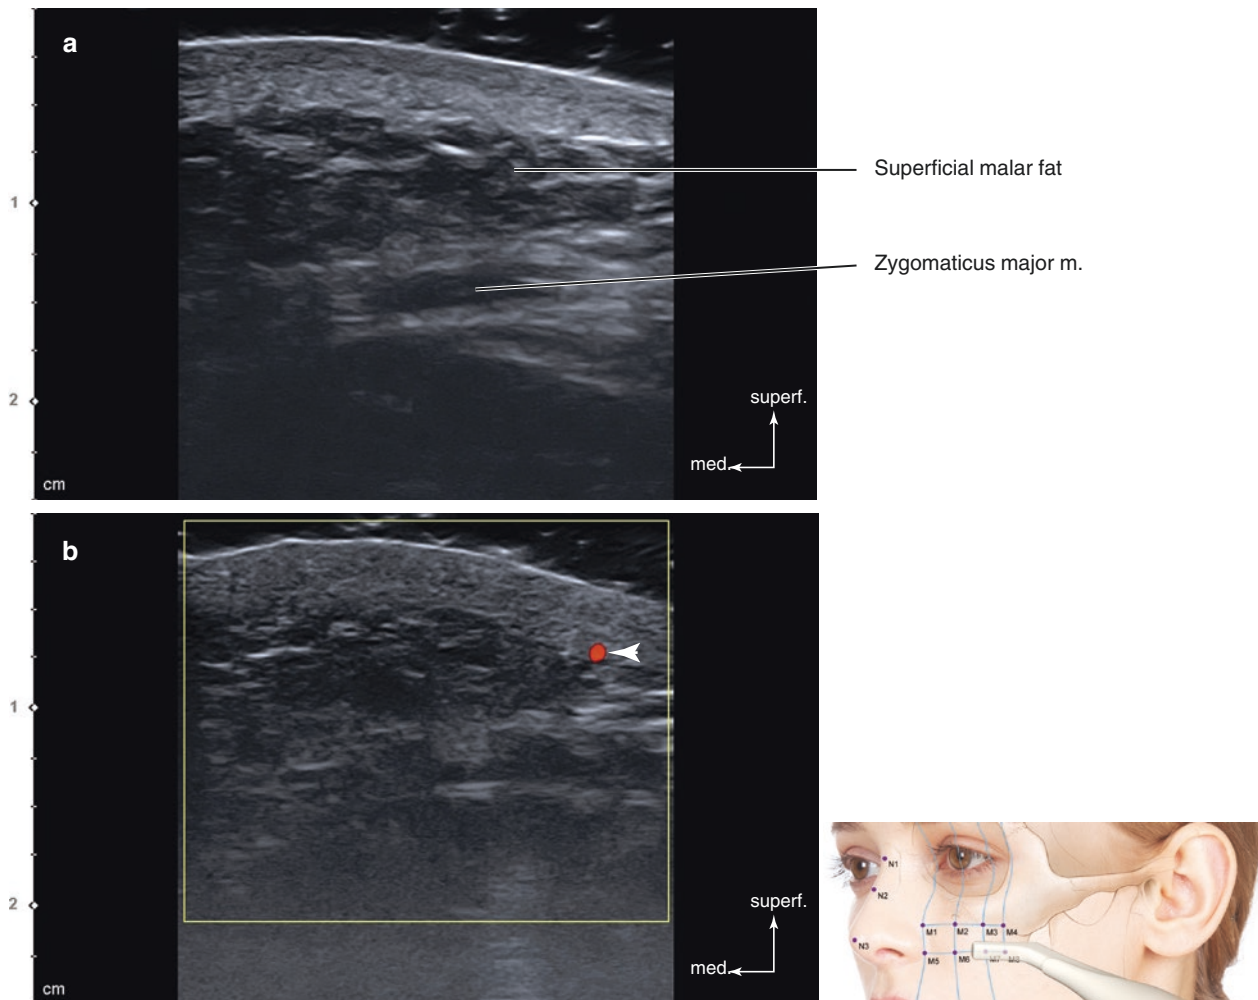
Ultrasonography on the intersection point of TL5 and PL4 (M8). (a) B mode (transverse view, 15 MHz by linear transducer) and (b) Doppler mode (transverse view, 15 MHz by linear transducer)
